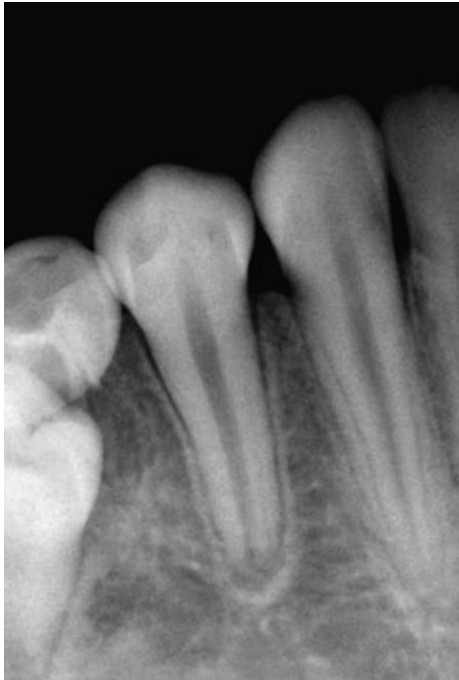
Periapical radiograph of contralateral premolar comparing root development at 11 months postoperative.
